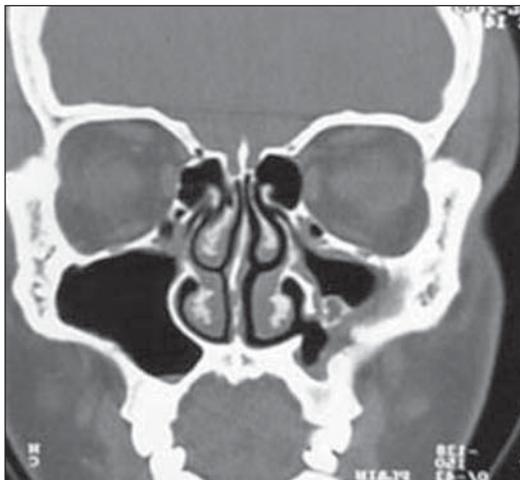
CT scan coronal section showing foreign body in left maxillary sinus with patent intranasal, antrostomy opening
